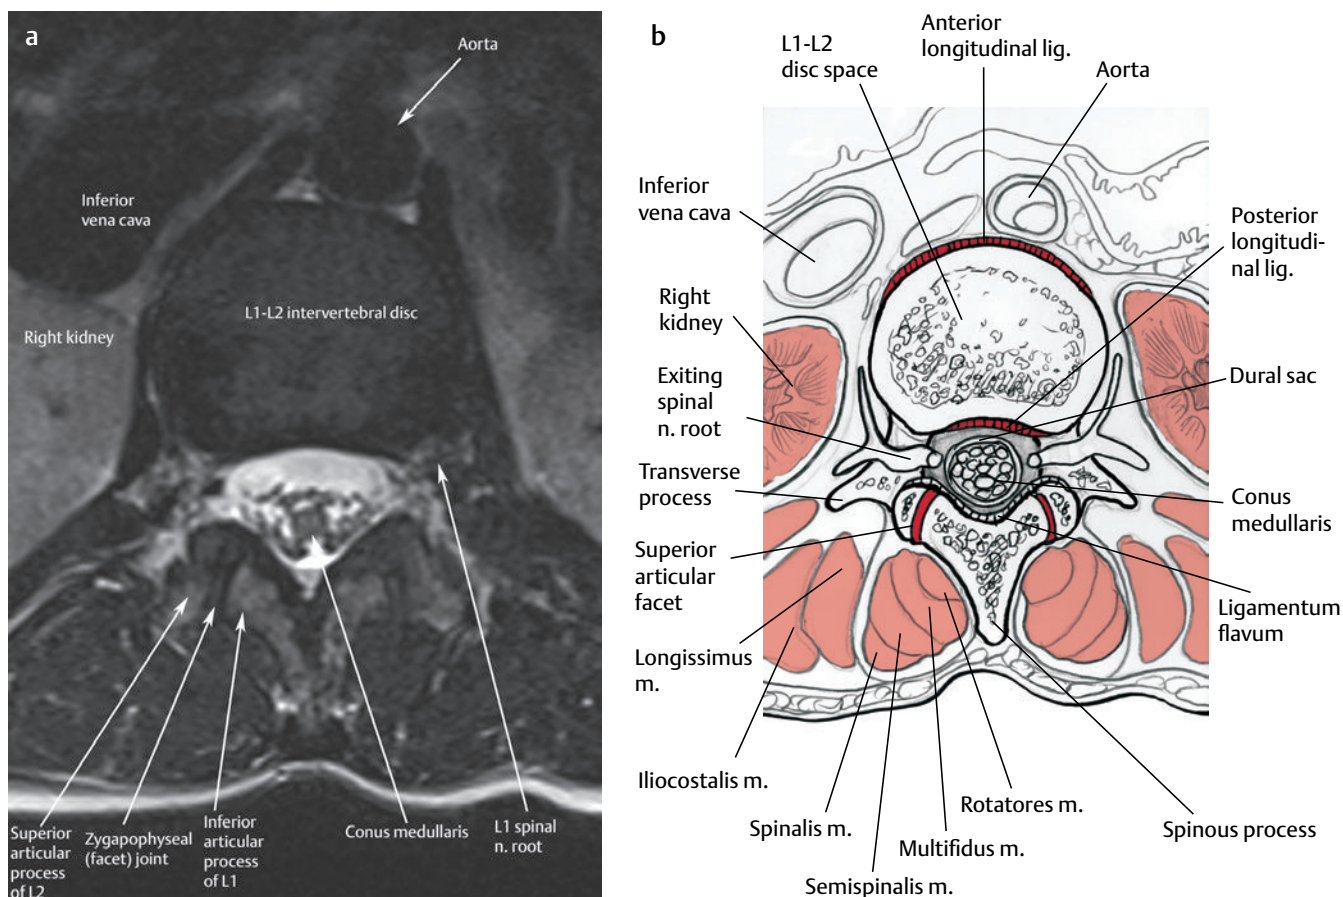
This (a) axial T2-weighted image and (b) artist's sketch of the spine at the level of the L1-L2 intervertebral disc show the conus medullaris and the L1 spinal nerve root, as well as the superior and inferior articular processes of the L1-L2 facet joint.[†]
